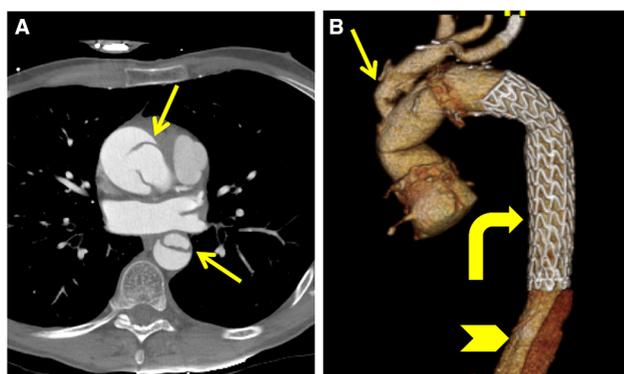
Trifurcated Y-graft of the aortic arch with frozen elephant trunk repair. a Axial CT images from a gated CTA demonstrates an acute Stanford Type A dissection. There is a dissection flap with intimal defect in the ascending aorta and descending aorta (straight arrows). The dissection flap also involves the aortic arch (not included on the field of view). b Follow-up imaging after frozen elephant trunk repair. A branching tri-furcating Y-graft (straight arrow) has been anastomosed to the ascending aortic graft, supplying the right brachiocephalic, left common carotid, and left subclavian arteries. A stent graft has been placed in the true lumen of the descending aorta (curved arrow). Note the residual dissection in the downstream descending aorta (arrowhead)
